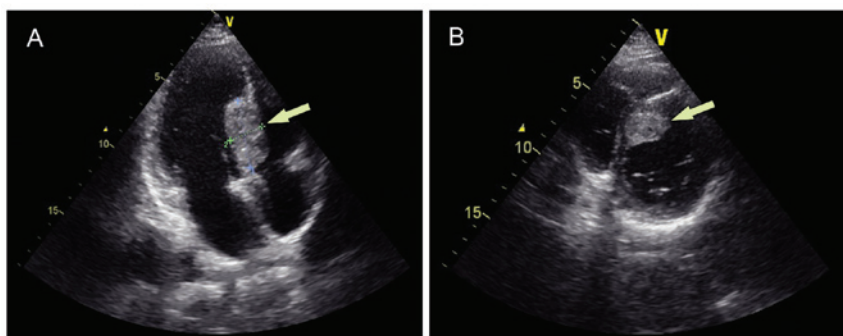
Transthoracic echocardiography showing a mass measuring 40 x 21 mm (arrows) within the interventricular septum in (A) the apical four chamber view, and (B) in the short axis view.
